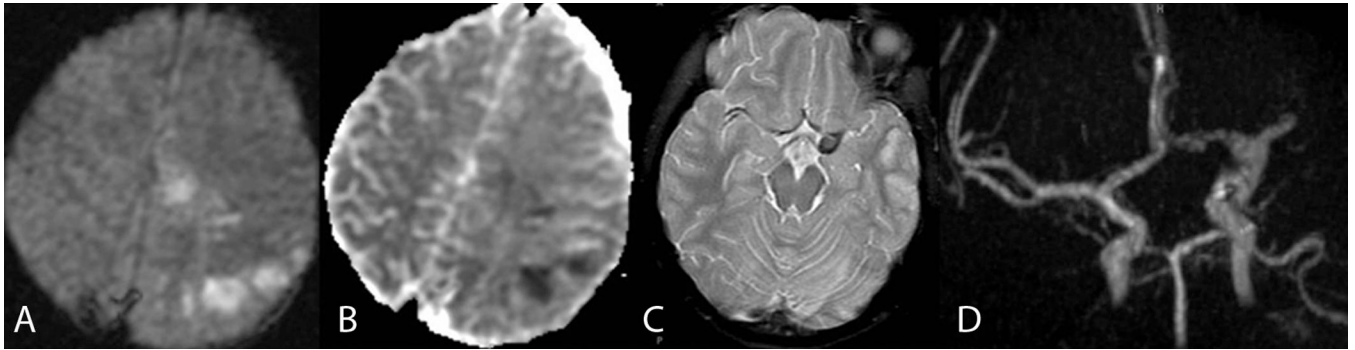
Patient #3. Small focal areas of restricted diffusion consistent with acute infarcts are noted in the left frontoparietal region on DWI and ADC map (A and B) due to left MCA occlusion. On T2-weighted axial image at a lower level (C) left temporal lobe cortical swelling and hyperintense signal are seen. The hypointense fusiform structure in the left sylvian fissure in (C) correlates to an aneurysm at left ICA terminus on MRA image (D).
